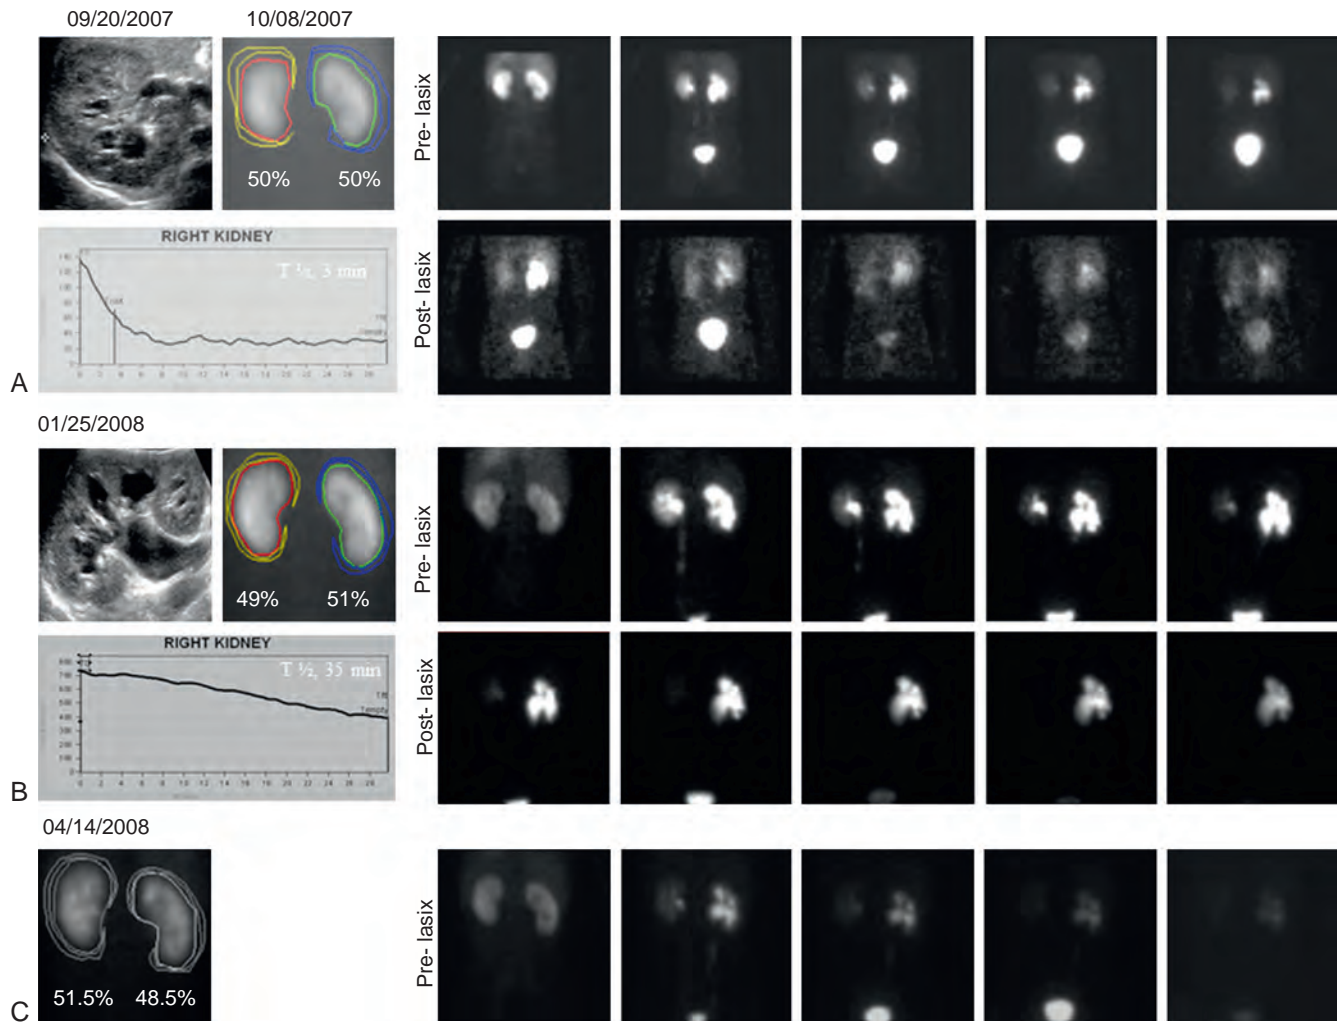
Ultrasound scan shows mild right hydronephrosis in a 7-year-old boy with right upper quadrant pain. A, Diuresis renogram shows nonobstructive drainage. The patient presented a second time with pain. This time, the sonogram showed increased dilation of the right collecting system. B, Diuresis renogram demonstrates worse drainage, and the patient reported pain after furosemide (Lasix) administration. C, After pyeloplasty, renography shows prompt spontaneous drainage; furosemide was not administered. T $\frac{1}{2}$, half-time.
